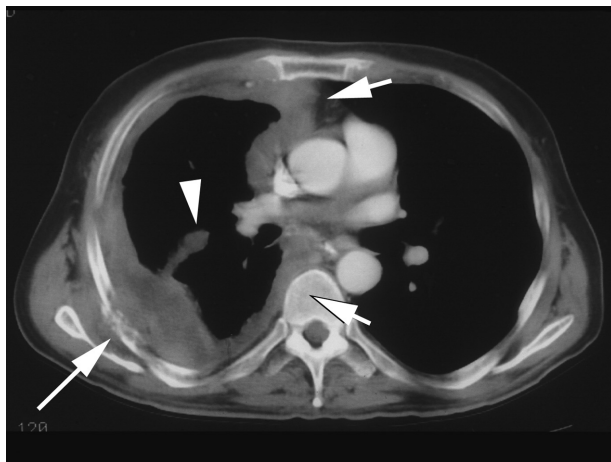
CT showing right MPM with characteristic diffuse pleural thickening, including involvement of the mediastinal pleura (*short arrows*) and oblique fissure (*arrow head*), with encasement of the lung and associated rib destruction (*long arrow*).
